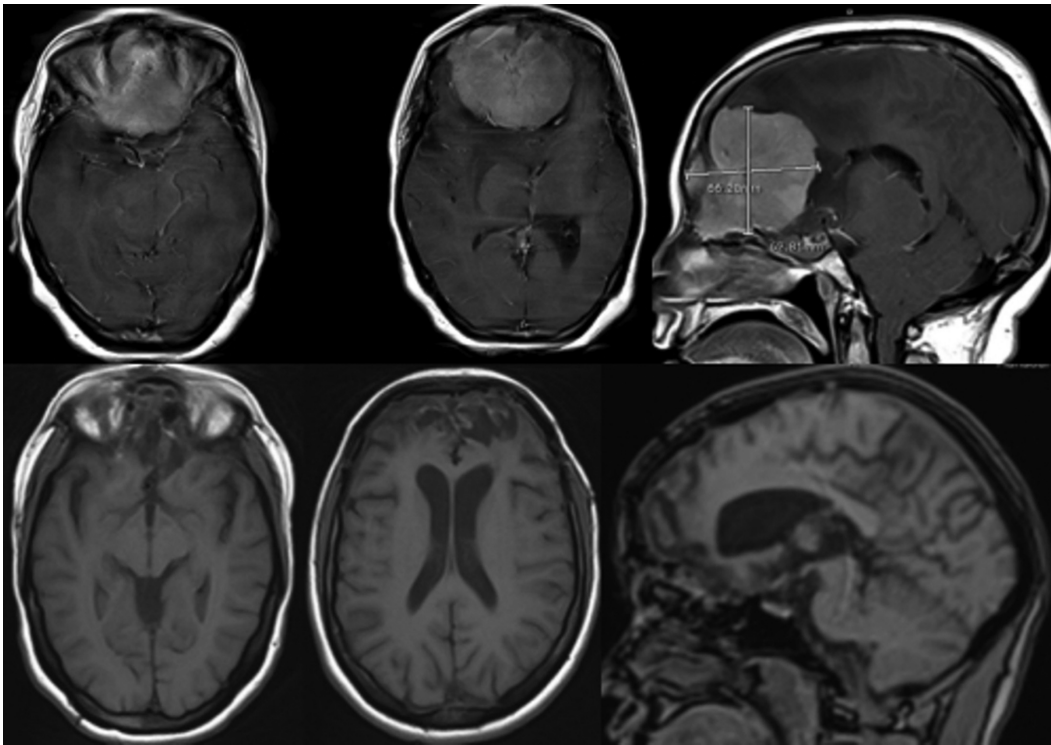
Upper row: a preoperative giant olfactory groove meningioma (OGM) that has been resected as shown in the lower row: a postoperative follow-up brain magnetic resonance imaging (MRI). A totally resected olfactory groove meningioma with an area of cerebrospinal fluid (CSF) and (encephalomalacia) was seen at the site of the operative bed with surrounding mild peritumoral edema.
